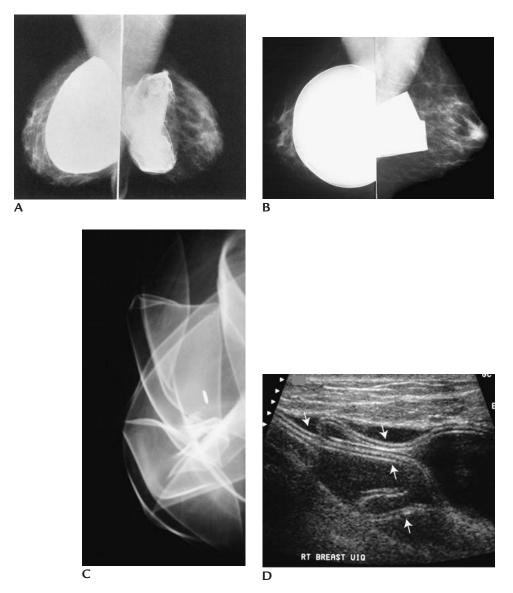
Saline implants. (A) Saline implants in a subglandular location. Left implant is folded on itself, partially collapsed. Capsular calcifications are present. (B) Different patient. Saline implants, subglandular in location. Left implant is collapsed. (C) Different patient. Partially collapsed right saline implant. (D) On ultrasound, implant shell is seen folded/collapsed on itself and there is fluid external to the folds either extravasated or reactive fluid.
